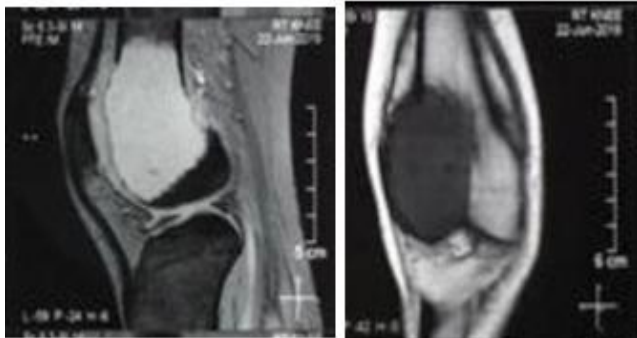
MRI scans showing gct in distal femur in both sagittal and coronal cuts
